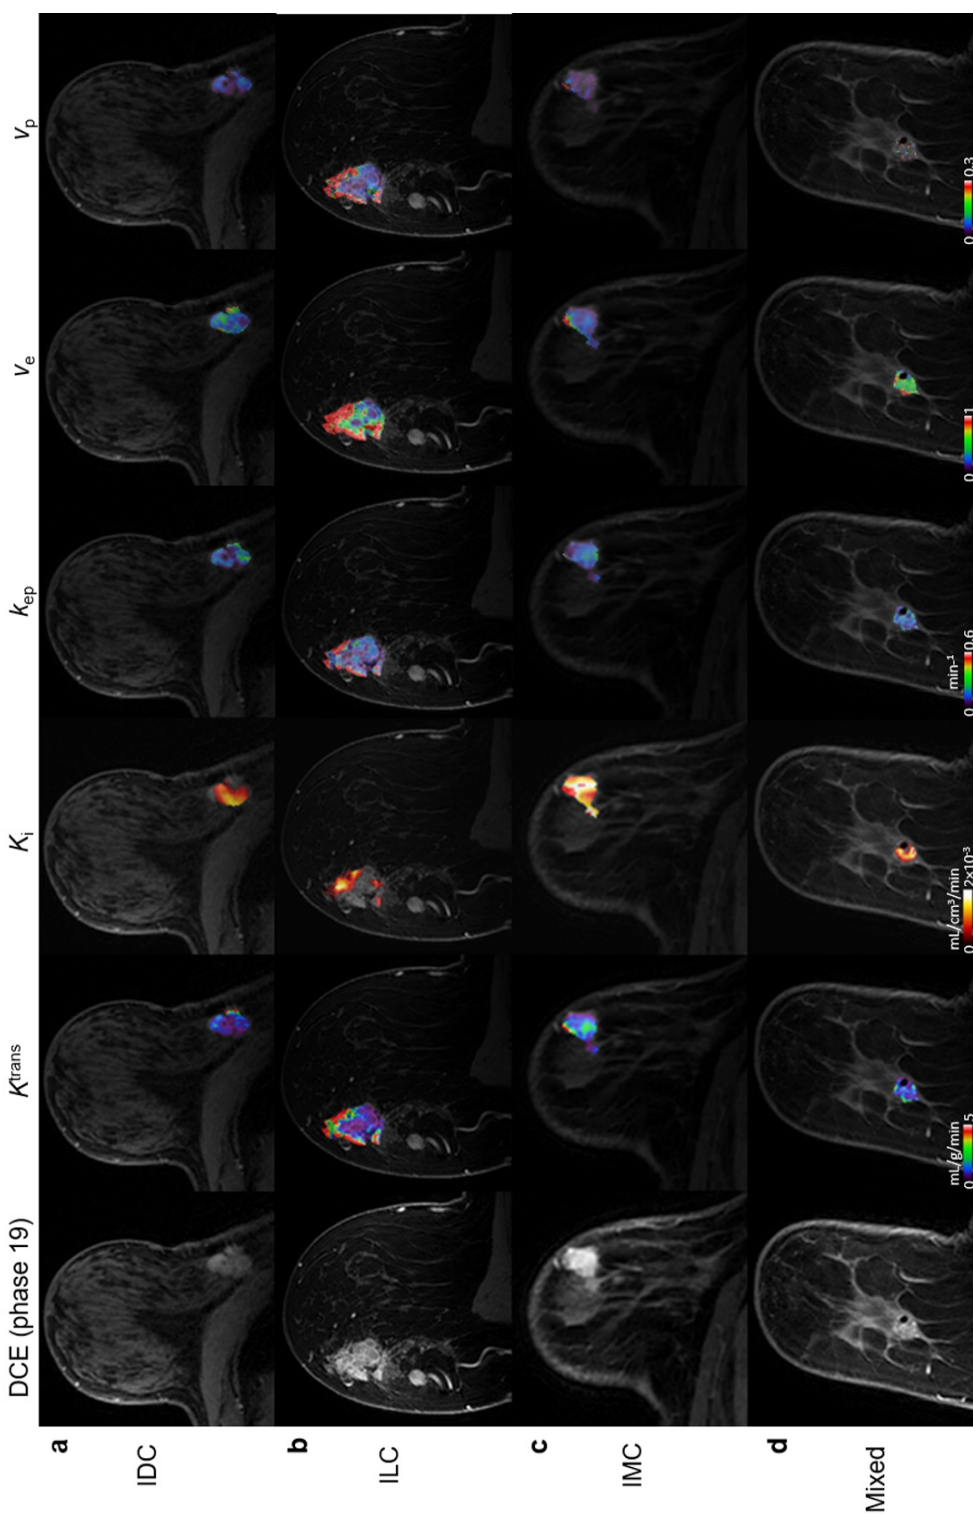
Axial images of the four representative patients shown in Fig. 3.4 with: (a) invasive ductal carcinoma (IDC); (b) invasive lobular carcinoma (ILC); (c) invasive mucinous carcinoma (IMC); and (d) carcinoma of mixed ductal and lobular type (Mixed). (*Left to right*) DCE-MRI image at peak enhancement, K_i^{trans} , K_{ep} , v_e and v_p maps. K_i^{trans} : contrast influx transfer rate (mL/g/min); k_{ep} : contrast efflux transfer rate (min^{-1}); v_e : fractional volume of extravascular-extracellular space; v_p : plasma fractional volume; K_i : ^{18}F -FMISO influx rate ($\text{mL/cm}^3/\text{min}$).
